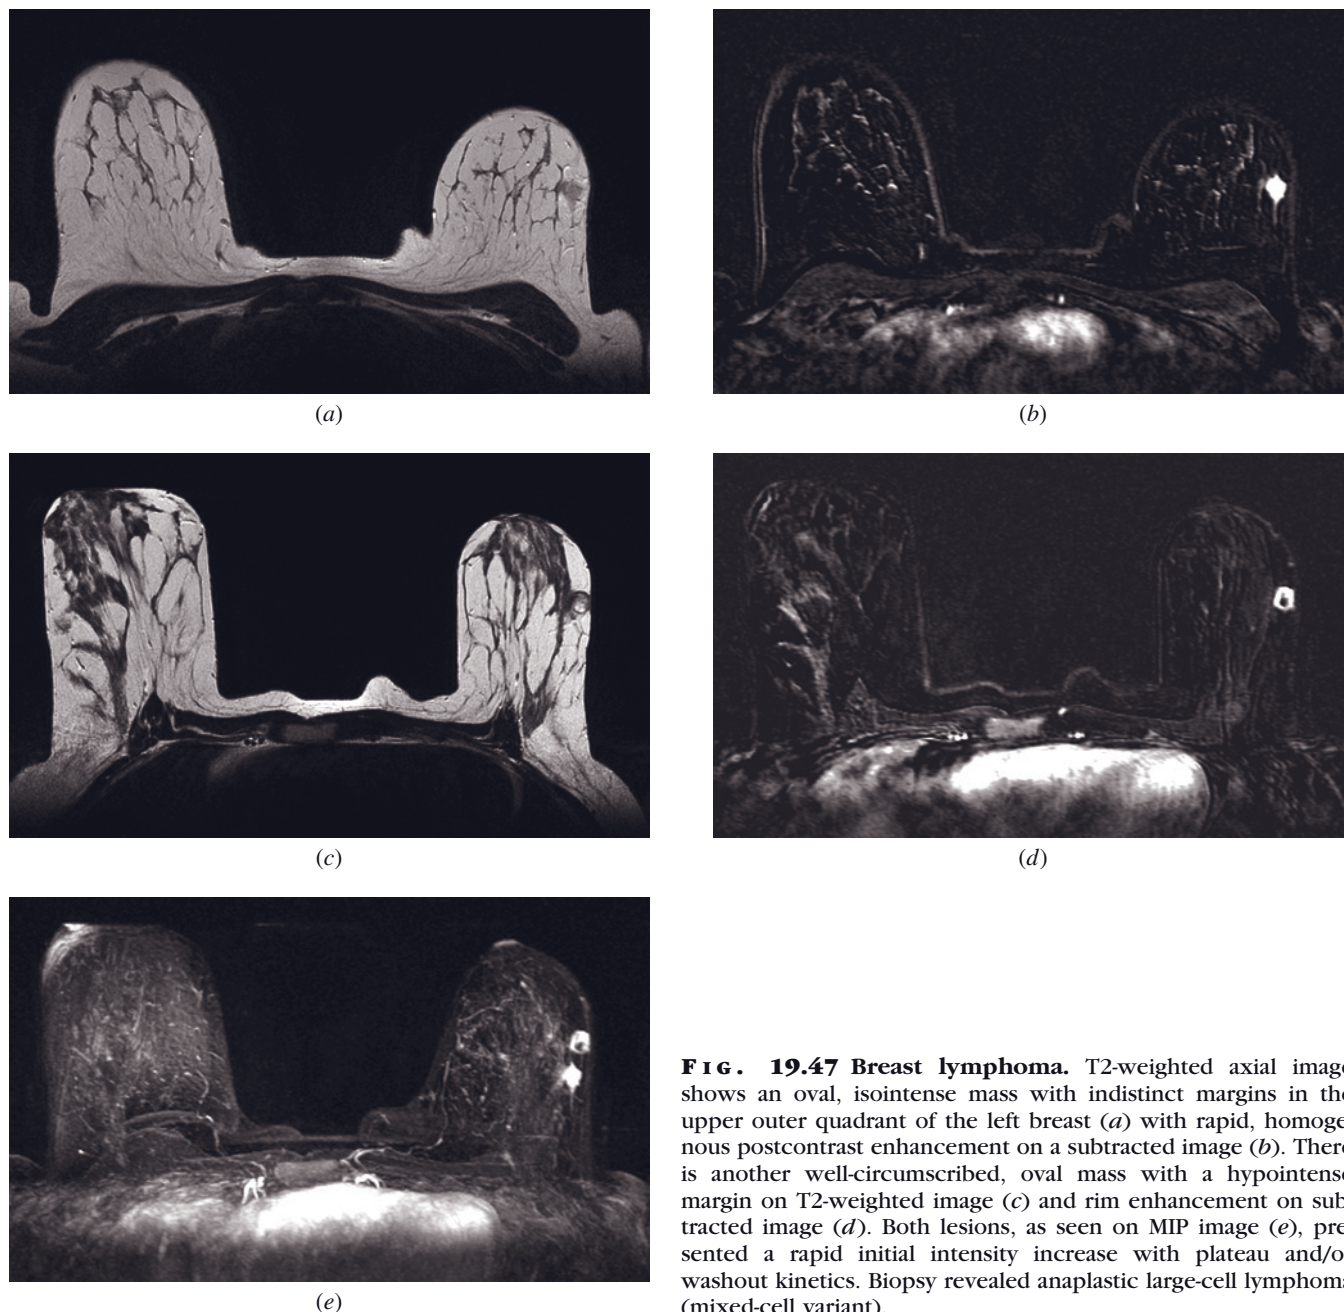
Breast lymphoma. T2-weighted axial image shows an oval, isointense mass with indistinct margins in the upper outer quadrant of the left breast (*a*) with rapid, homogeneous postcontrast enhancement on a subtracted image (*b*). There is another well-circumscribed, oval mass with a hypointense margin on T2-weighted image (*c*) and rim enhancement on subtracted image (*d*). Both lesions, as seen on MIP image (*e*), presented a rapid initial intensity increase with plateau and/or washout kinetics. Biopsy revealed anaplastic large-cell lymphoma (mixed-cell variant).
